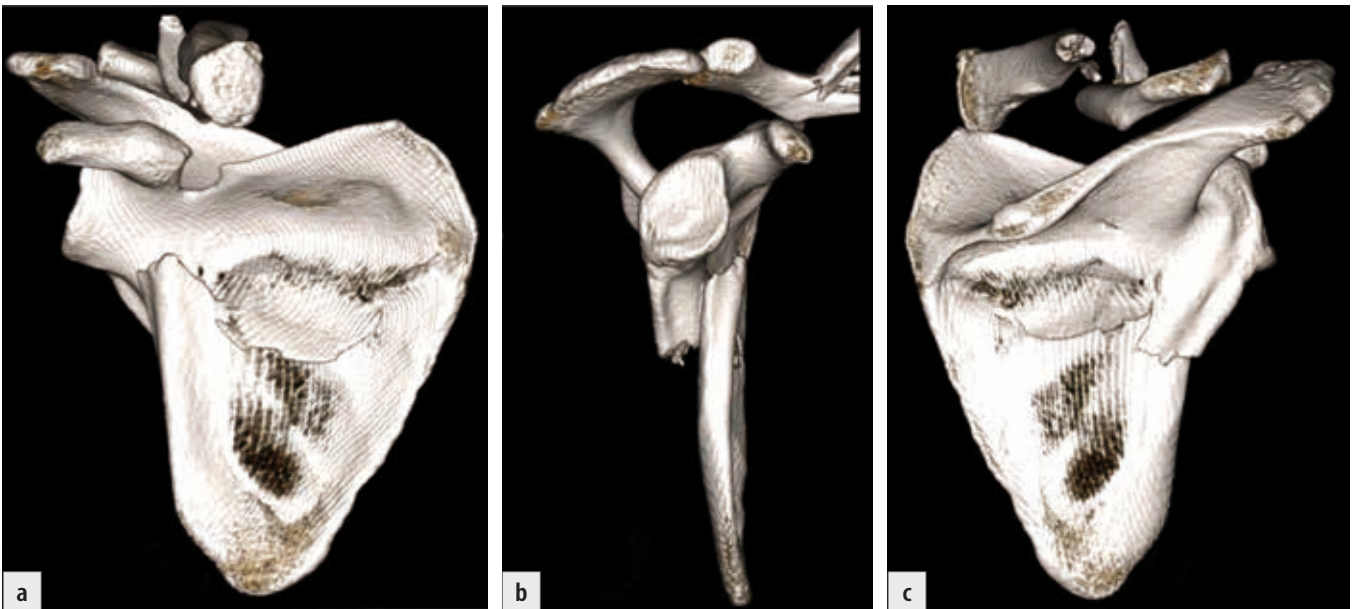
Two-part infraspinous fracture of the scapular body combined with a clavicular shaft fracture, a case from Fig. 10-17: a-c) 3D CT reconstruction, d) post-injury radiograph, e) postoperative radiograph.
